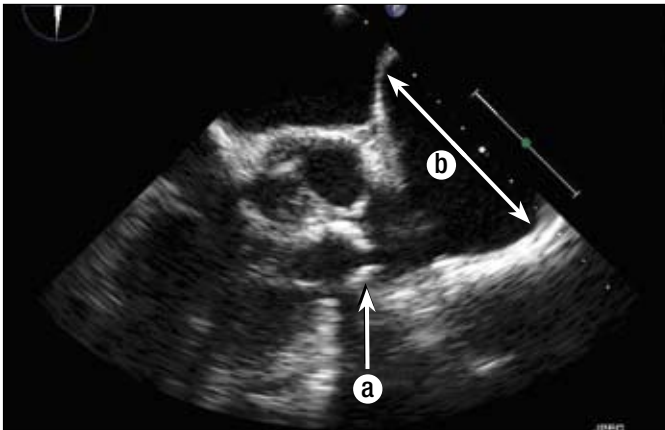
Transesophageal echocardiogram showing (a) a severely calcified and stenotic pulmonic valve and (b) a dramatic poststenotic pulmonary artery.
